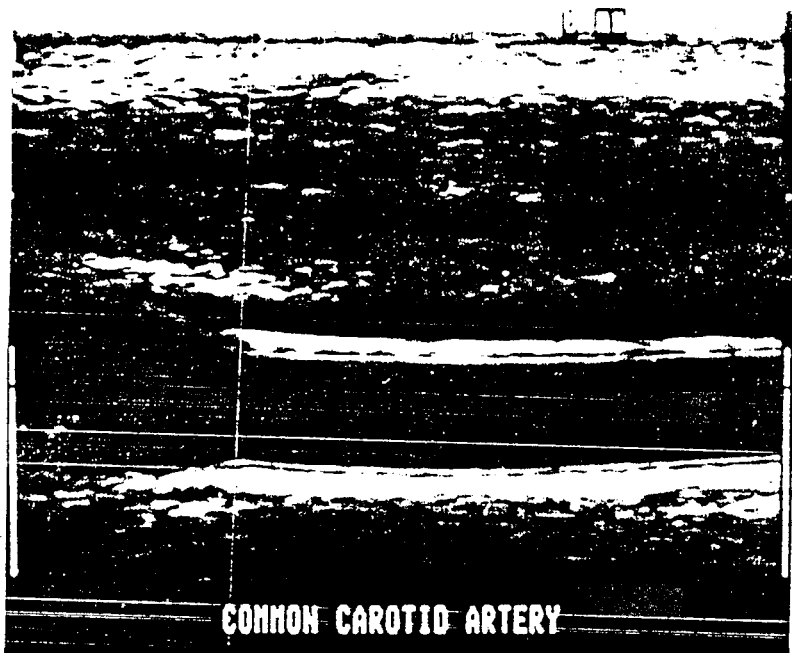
A high resolution ultrasound image of the artery in longitudinal section. The echogenic intima and echolucent media can be readily identified.
